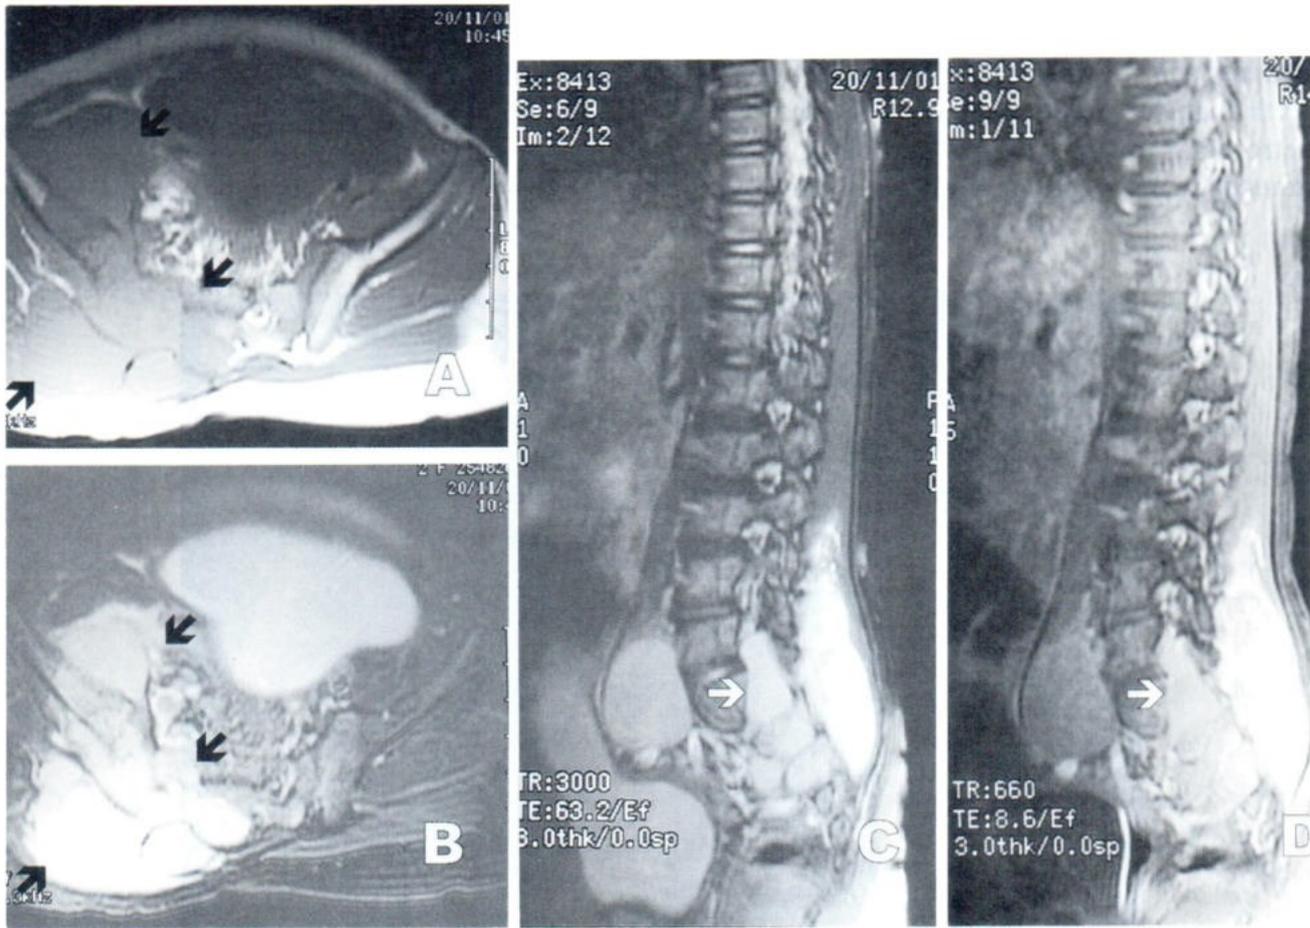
Ewing sarcoma. Axial T1-weighted image (A) shows a slightly hyperintense mass (black arrows) compared to muscle surrounding the right ilium. On axial and sagittal FSET2-weighted image with fat suppression (B and C), the mass (black arrows) is hyperintense. Invasion of the right ilium, invasion of the right side of the sacrum, and invasion into the sacral foramina (white arrow) and spinal canal are seen. Postcontrast sagittal T1-weighted image with fat suppression (D) shows heterogeneous enhancement of the mass.
